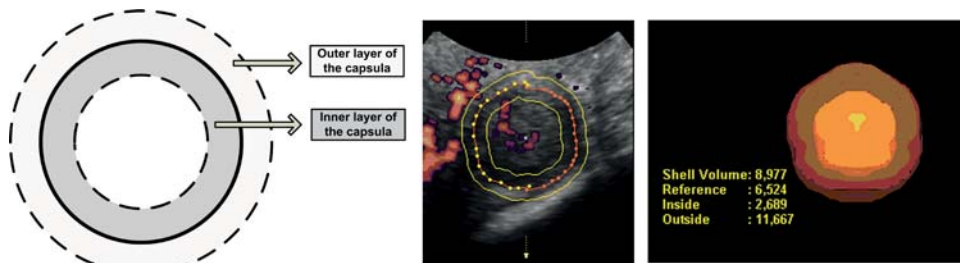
Method of volume measurement of the capsule of the fibroid using shell mode of 3D Power Doppler. The shell contour mode was used to measure vascularity of the capsula. The shell contour mode consists of an inner outline and an outer outline at the border of the fibroid with a total thickness of 0.5 cm. The shell contour mode can be switched on and off during volume measurement with both automatic and manual contour modes. When a volume is constructed, the shell contour mode can be switched to off, inside (inner layer on), outside (outer layer on) and symmetric (both inner and outer layer on).
